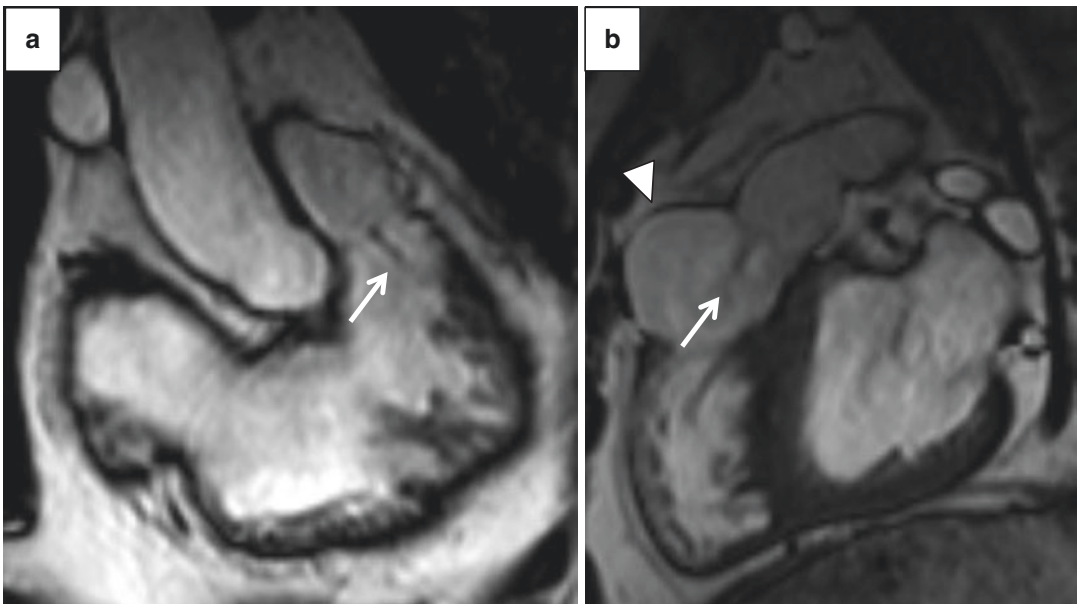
Same patients as in Fig. 14. MRI bright blood (SSFP) images in 2-chamber view of the right ventricle (a) and RVOT view (b), demonstrating a flow-related jet
